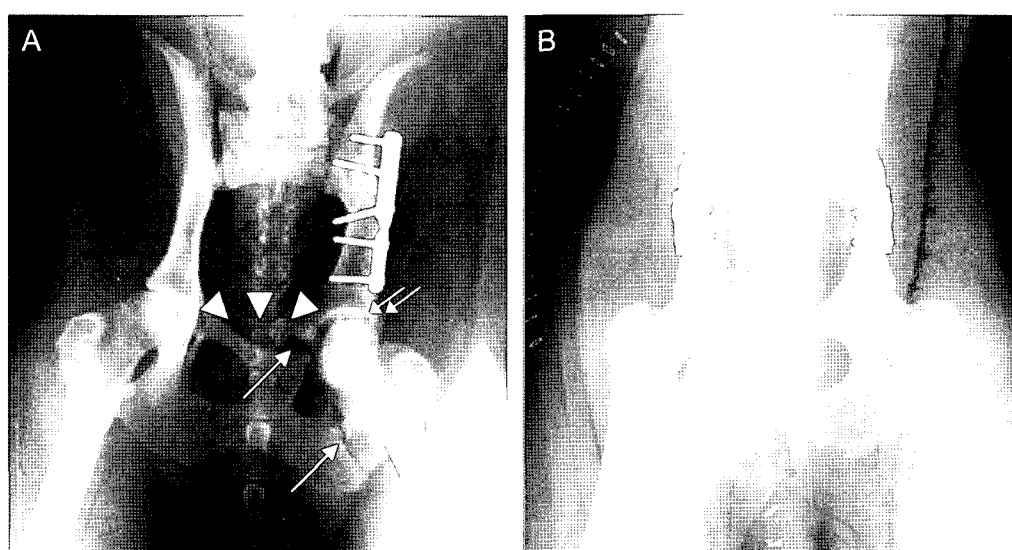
Postoperative radiographs of unilateral TPO (A) and modified TPO (B). Note that non-union of pubic and ischial osteotomy sites (single arrow), deformation of pelvic canal (arrow heads), over-coverage of hip joint (double arrows) in unilateral TPO.
